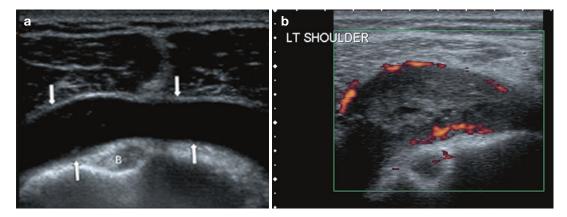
Ultrasound of the subacromial-subdeltoid bursa: (a) anechoic fluid distension bursa (*arrows*) in a patient with bursal distension secondary to rotator cuff
